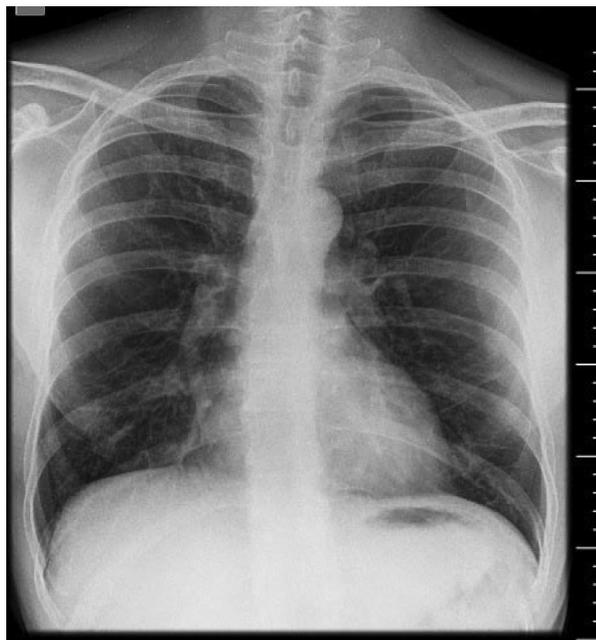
Chest radiograph PA view after 1 month of appropriate therapy showing resolution of lesion
